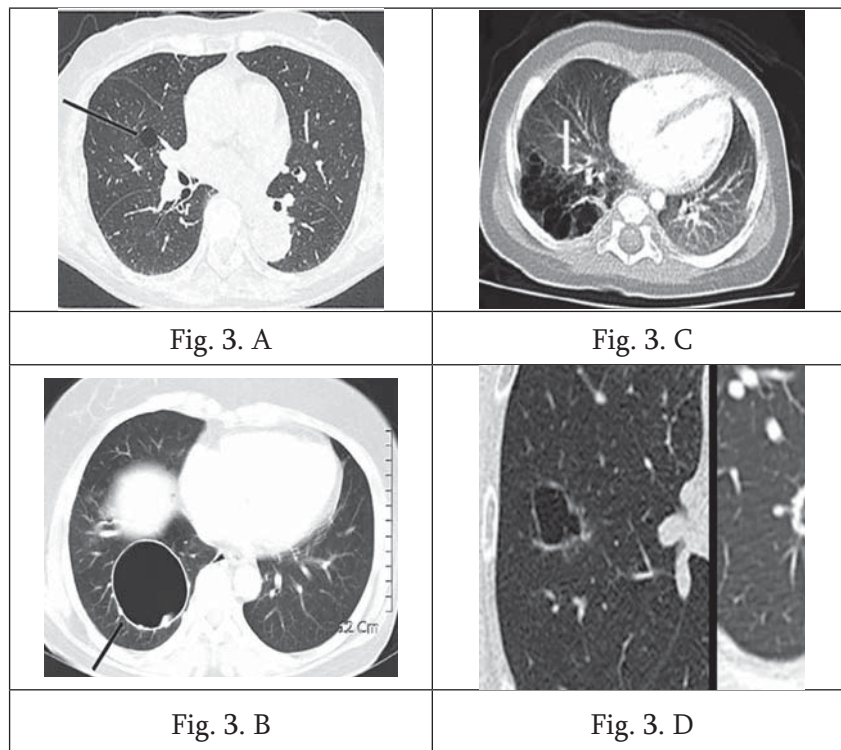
A. Incidental cyst in 66-year-old woman. CT shows round 14-mm-sized thin-walled cyst (arrow) in right middle lobe. B. congenital cystic adenomatoid malformation (CPAM) in a 10-month-old infant. several small cysts (arrow) in the right lower lobe. C. Bronchogenic cyst in 55-year-old woman. CT shows well-defined air-filled cyst (arrow) in right lower lobe, suggesting bronchogenic cyst. D. Surgically proved solitary cystic lung cancer.
